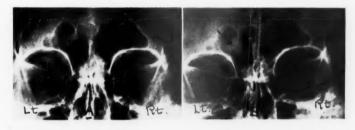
X-ray pictures demonstrating (a) normal sinuses taken July 6, 1943; (b) x-ray findings of submucosal hematoma following barotrauma received August 11, 1943 (Case 2).
